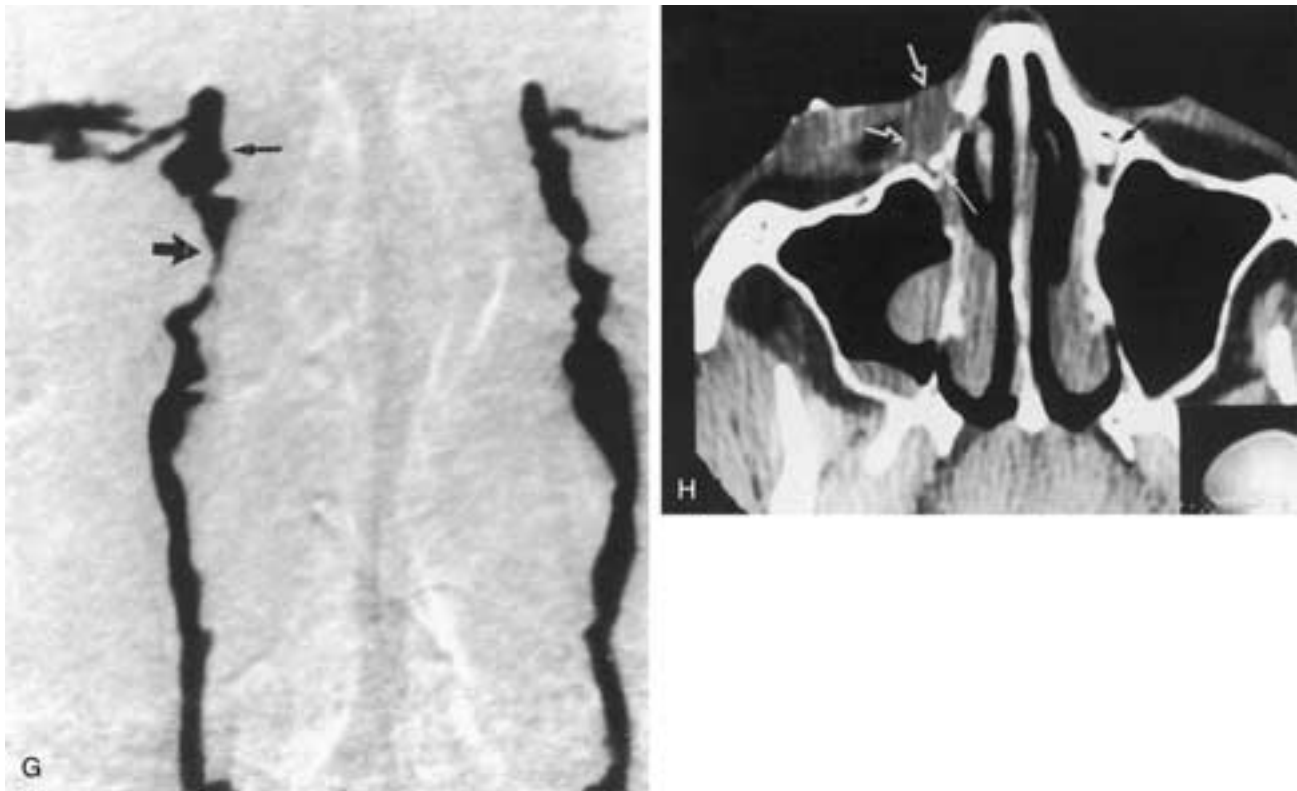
Continued. G and H, Mild prominence of the right inner canthus. G, DCG. Mass indenting the proximal right nasolacrimal duct (*larger arrow*) from the lateral aspect with mild distention of the lacrimal sac (*thin arrow*). H, Axial CT-DCG shows a soft-tissue mass in the right inner canthus (*open arrows*) displacing the lacrimal sac (*thin arrow*) posteromedially within the nasolacrimal fossa. Normal left NLDS (*black arrow*). Pathology: lymphocytic lymphoma in the wall of the lacrimal sac and duct. (Note also the nasopharyngeal lymphomatous mass.) (Courtesy of Dr. Nasir Jaffer, Toronto, Canada.)
